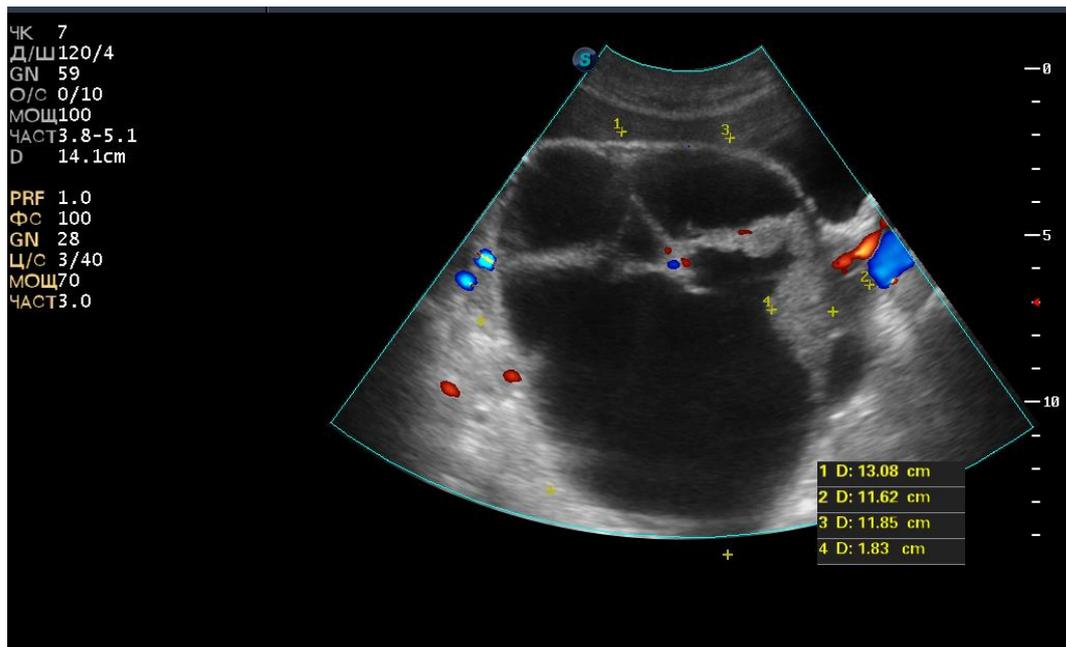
Patient 31 years old. On the sonogram of the small pelvis , a multi-chamber cystic-solid formation 13x11 cm in size with enhanced vascularization in the CDI mode is located.
